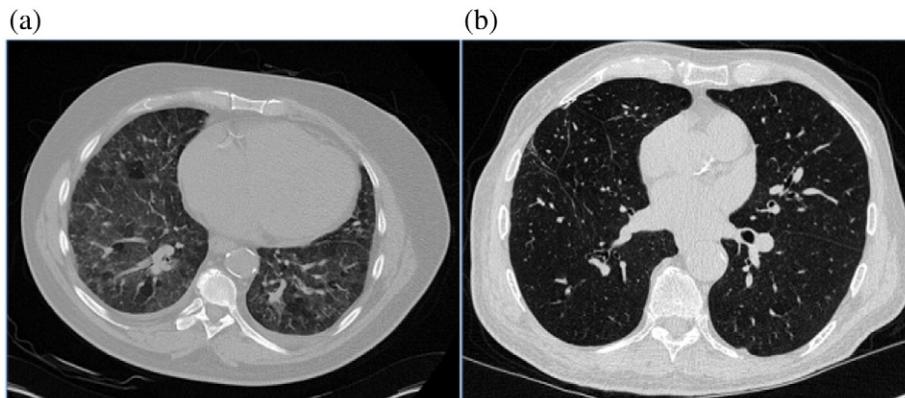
(a) CT of ADHF patient with pulmonary edema (b) CT of ambulatory non-heart failure patient (dry lungs).
